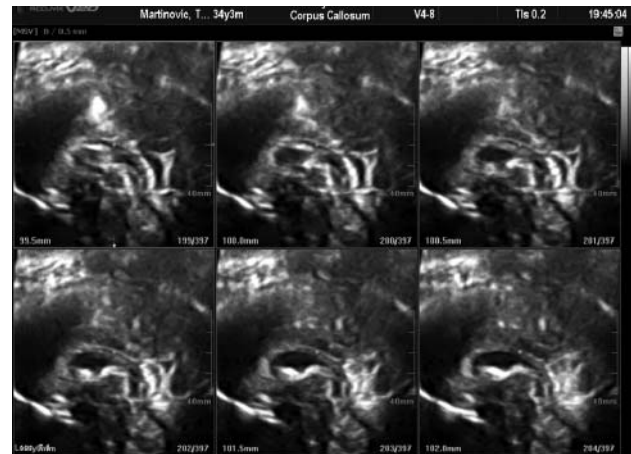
3D/4D multislice ultrasound of fetal brain.
